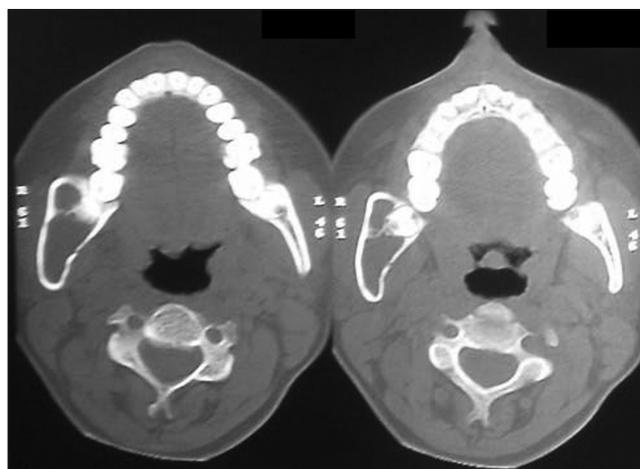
Axial computed tomography section shows a well-defined, expansile, cystic, multilocular hypodense lesion
